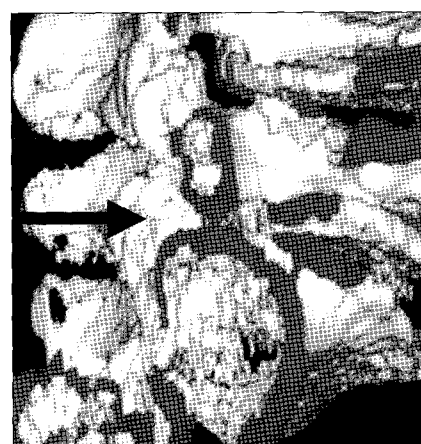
Preoperative 3D reconstruction computed tomography shows narrowing of L5-S1 foramen.
